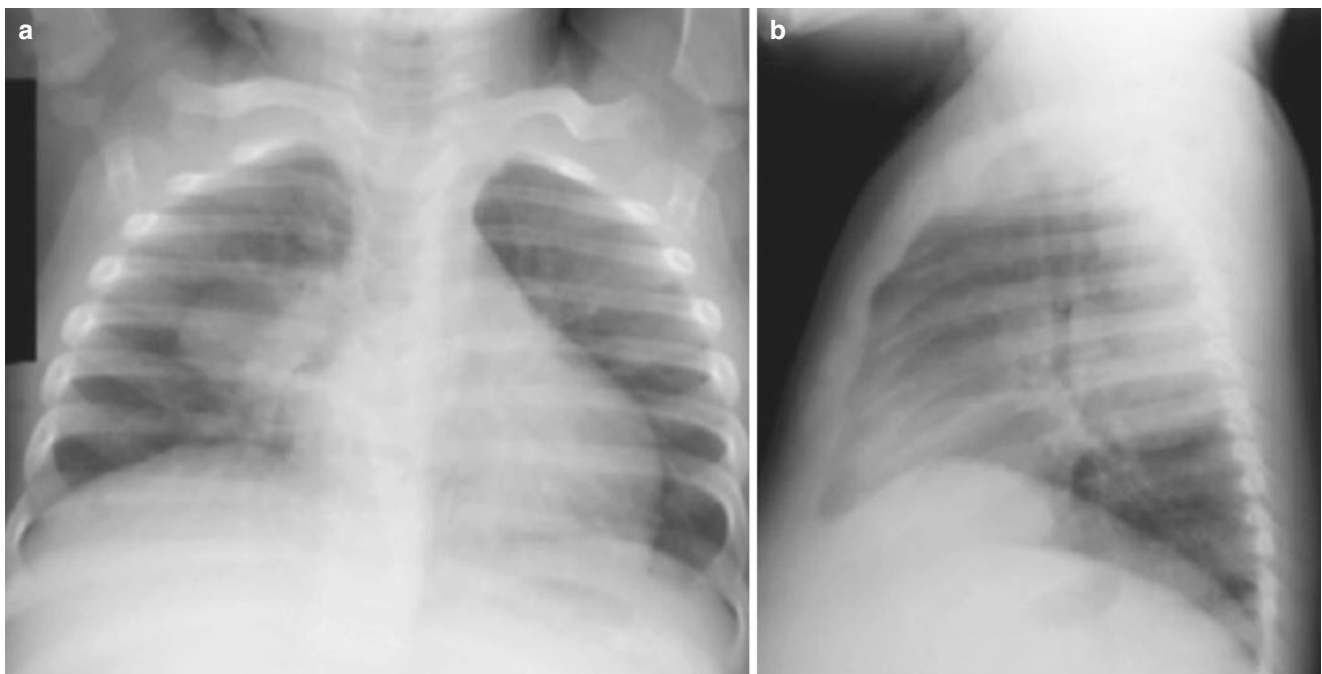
Round pneumonia in a 5-year-old boy who presented with cough and fever. (a) Frontal radiograph and (b) lateral radiograph show a round mass-like opacity located in the superior segment of the right
